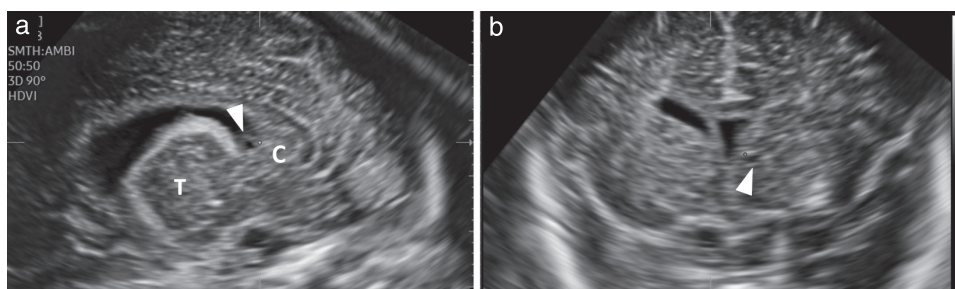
Three-dimensional ultrasound images at 21 weeks' gestation in fetus with cytomegalovirus infection (Case 4), showing small cyst (arrowhead) of germinal matrix in parasagittal (a) and coronal (b) planes. C, nucleus caudatus; T, thalamus.
